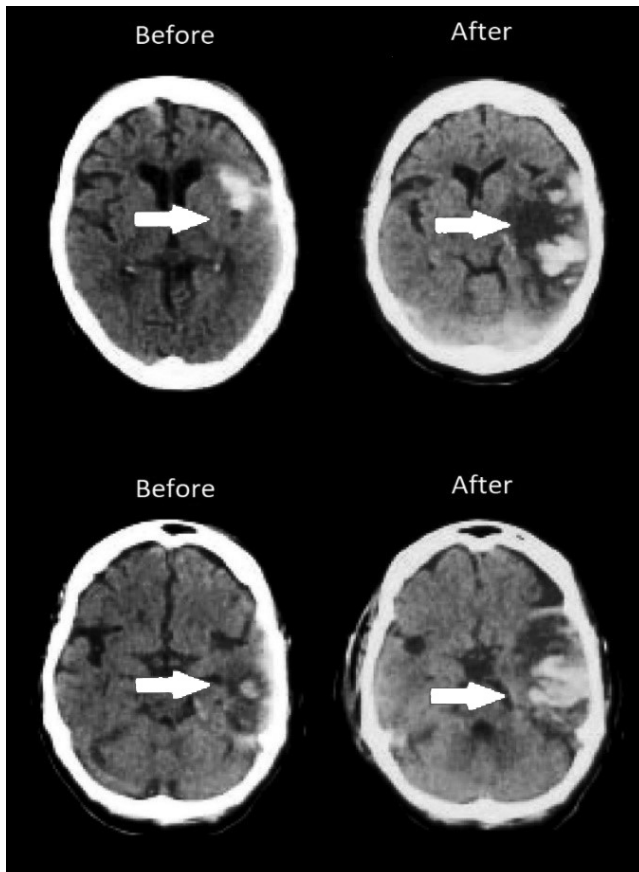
Showing initial CT scan and repeat CT scan of a patient (showing two sections side by side):
